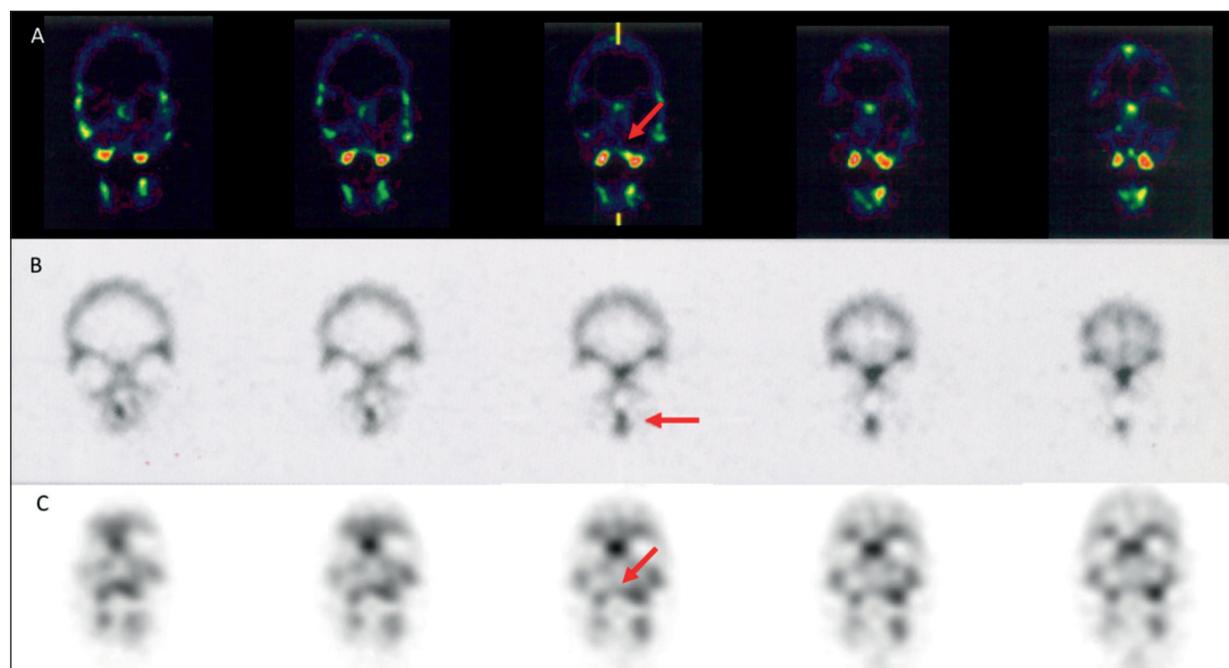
(A) Coronal images of the SPECT bone scintigraphy performed before treatment show an area of lack uptake of ^{99m}Tc-MDP along the midline of the maxillary bone (red arrow). (B) Coronal images of bone scintigraphy performed 6 months after the treatment show intense uptake of ^{99m}Tc-MDP in the same previously missing site (red arrow). (C) The Coronal images 8 years after the surgical procedure show the homogeneous distribution of ^{99m}Tc-MDP in the maxillary bone.
